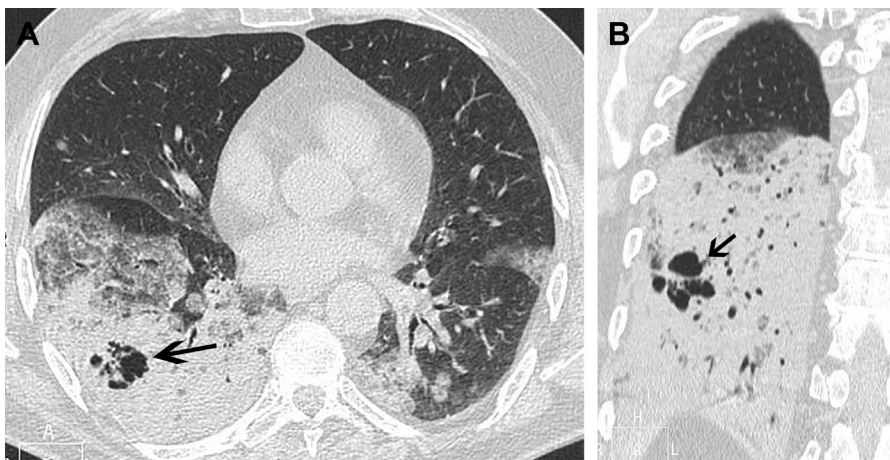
Pneumococcal pneumonia. (A) Axial and (B) coronal CT images show heterogenous lobar consolidation with irregular air lucencies caused by necrosis (arrows).
